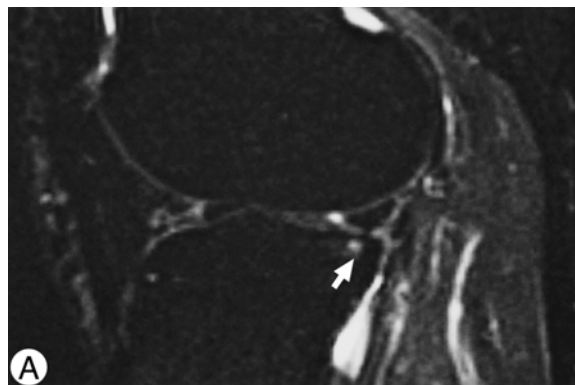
(A) A sagittal T2-weighted turbo STIR MR image shows a grade 1 subchondral lesion (arrow) at the dorsal aspect of the lateral tibial condyle at the baseline examination in this 57-year-old woman. The corresponding MR image after 25 months, (B), shows that the lesion has disappeared.
